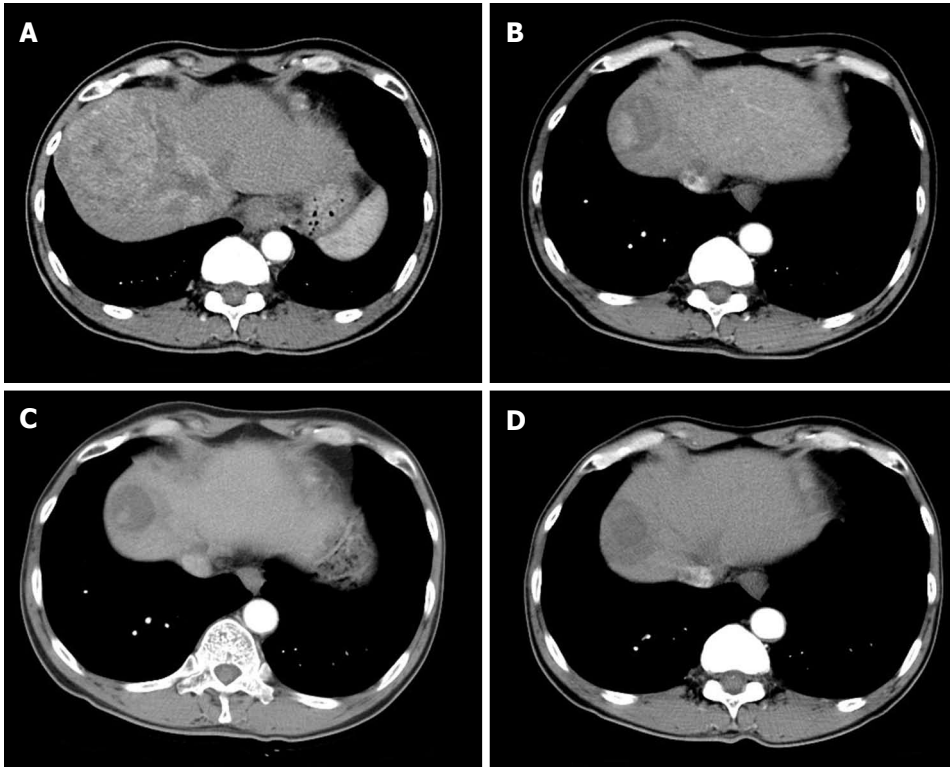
Arterial phase scans of contrast enhanced multiphase computed tomogram of abdomen. A: Baseline abdominal computed tomogram (CT) scan showed 12.5 cm sized enhancing mass in segment 8 with tumor thrombus in middle, right hepatic vein extending to intrahepatic inferior vena cava; B: The size of tumor decreased to 4.8 cm with 2.7 cm sized enhancing nodule in tumor in 6 mo-follow-up CT scans; C: The tumor size further decreased to 3.0 cm with 1.5 cm sized enhancing nodule within tumor in 12 mo-follow-up CT scans with resolution of tumor thrombus in hepatic vein and portal vein. D: There was no arterial enhancing viable portion in ablated tumor in abdominal CT scans 6 mo after radiofrequency ablation.
